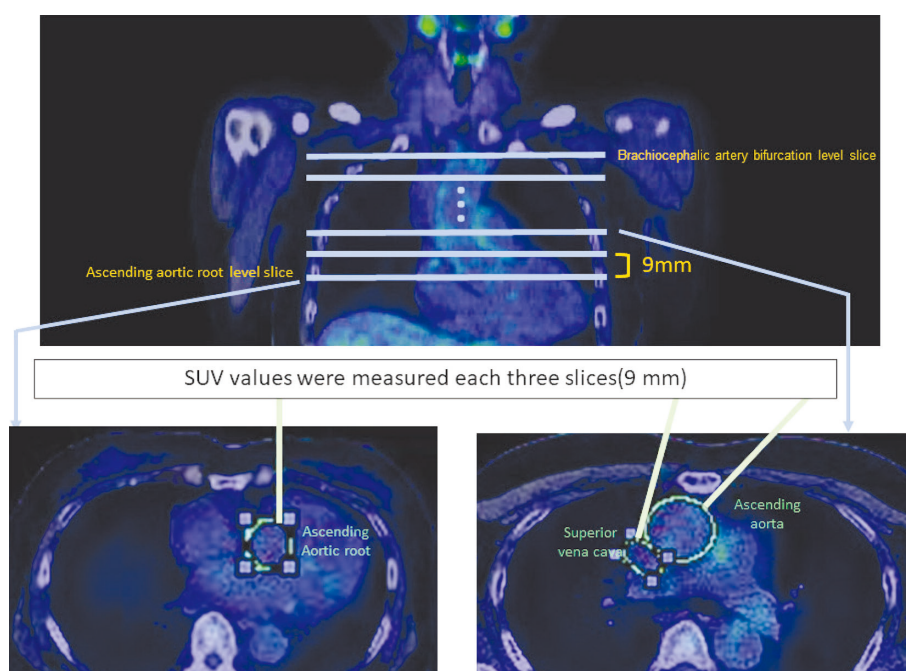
Example of site where SUV values were measured.
